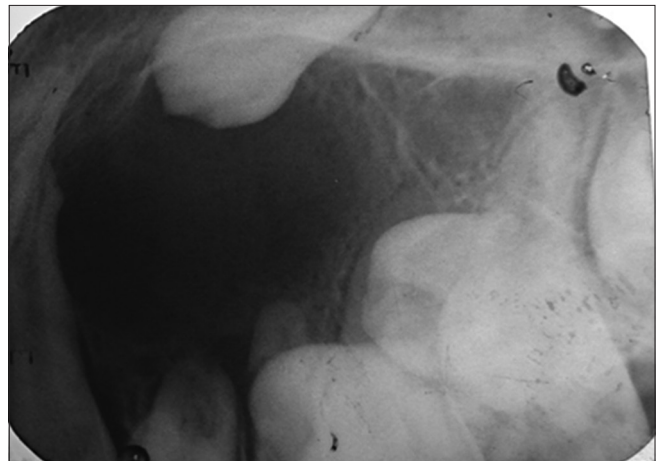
IOPA shows a well- defined radiolucency in periapical region extending from mesial border of 12 without involving apex of 11 until mesial border of 16
